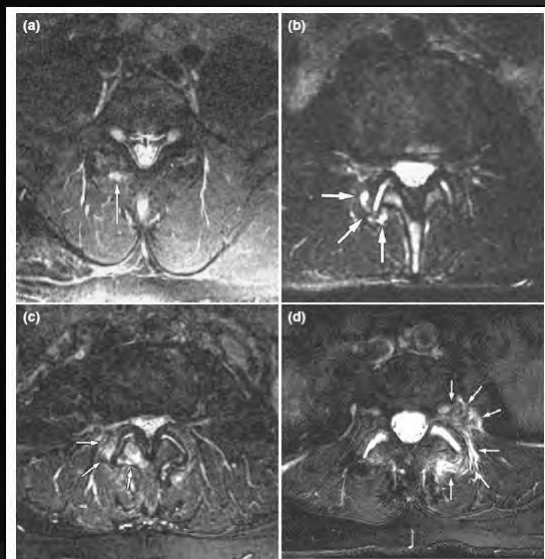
Grading facet synovitis: fat-saturated T2-weighted imaging. (a) Grade 1. Small T2 hyperintensity (arrow) in the posterior-inferior capsule of the right L4-5 facet joint represents earliest sign of facet synovitis. (b) Grade 2. T2 signal hyperintensity (arrows) in posterior portion of right L3-4 facets involves less than 50% of the facet joint perimeter. (c) Grade 3. T2 signal hyperintensity (arrows) involves greater than 50% of facets as well as the right L4 lamina. (d) Grade 4. Extensive abnormal T2 signal (arrows) involves and surrounds the L4-5 facets on the left with abnormal T2 hyperintense tissue within and lateral to the left L5-S1 neural foramen. Note more fluid than normal in both L5-S1 facet joints.
